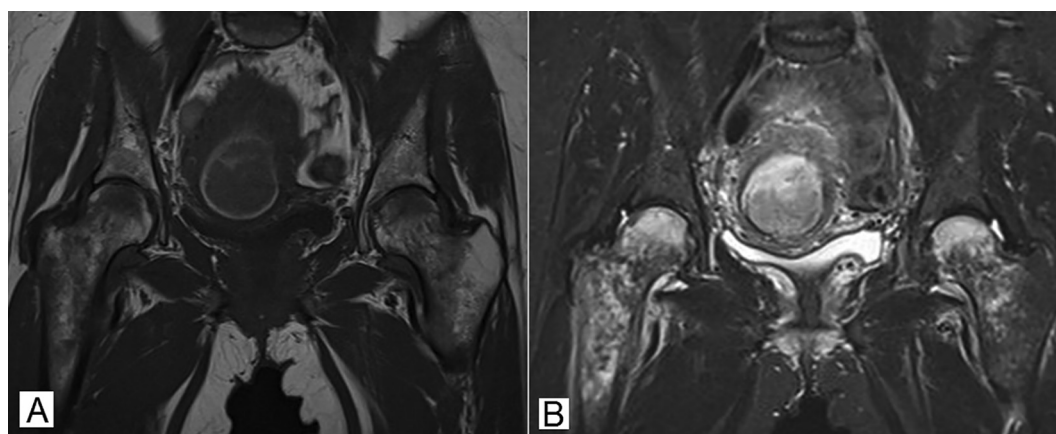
Magnetic resonance imaging (MRI) of pelvis, baseline scan. Findings in line with bone marrow oedema (BMO). A. Coronal T1-weighted image, areas of low signal intensity involving the head, neck, and intertrochanteric regions of both femurs are seen, more pronounced on the right; B. Short tau inversion recovery (STIR) image, areas of high signal intensity corresponding to the areas of low signal intensity as shown in A.
